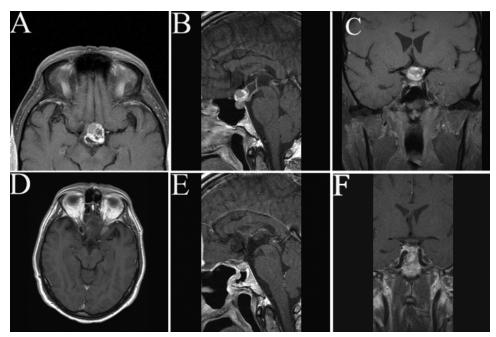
Preoperative (A–C) and postoperative (D–F) contrast-enhanced MR images of a patient with a craniopharyngioma. Axial (A), sagittal (B), and coronal (C) views of a 2.0-cm (solid) and 2.5-cm (cystic) tumor. Axial (D), sagittal (E), and coronal (F) views obtained at the 3-month follow-up showing a GTR of the lesion.
